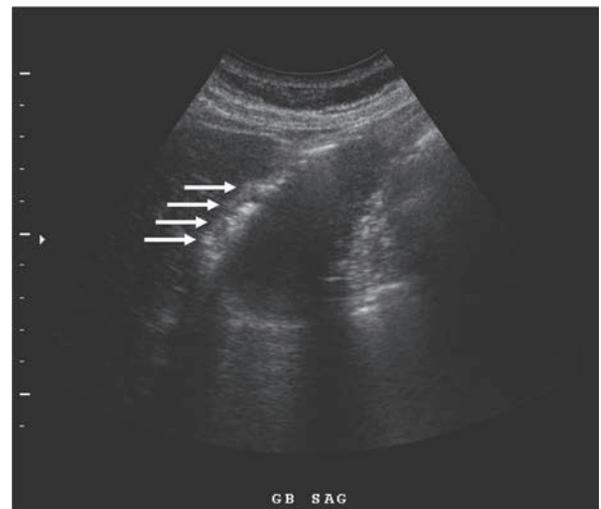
Ultrasonography revealed a hyperechoic appearance secondary to gas in the gallbladder wall (arrow) that was associated with a "tail ring-down artifact".
